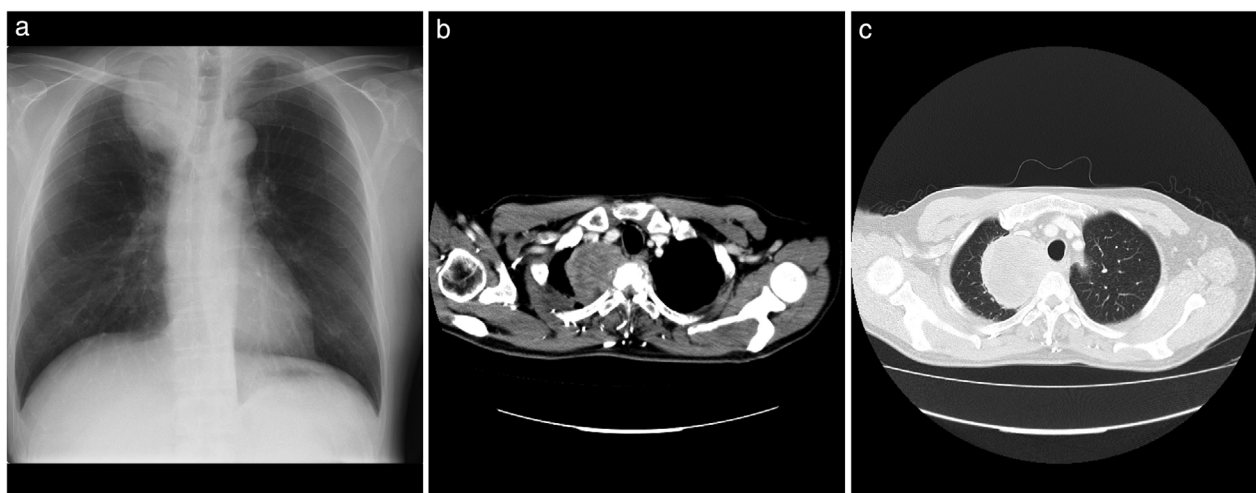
(a) The chest radiography revealed a mass shadow in the right upper lung. (b,c) The chest high resolution computed tomography (CT) scan showed a tumor in the right upper lobe. The tumor size was 70 × 69 mm with a necrotic center.
